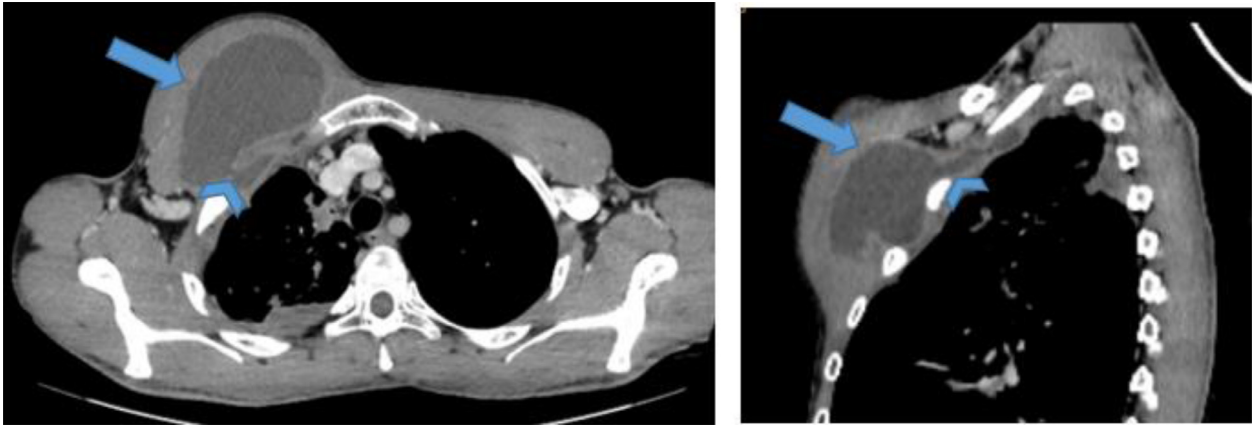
Chest CT: Right chest parietal cystic lesion (Arrow) communicating with homolateral pleural effusion (Arrowhead).
